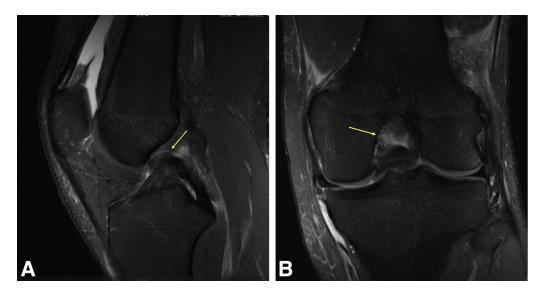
(A) Sagittal T2weighted magnetic resonance imaging (MRI) of the left knee. The MRI demonstrates proximal avulsion of the anterolateral bundle of the posterior cruciate ligament (PCL). The yellow arrow indicates the avulsed PCL fibers. (B) Coronal T2weighted MRI of the left knee. There is proximal avulsion of the anterolateral bundle of the PCL with edema at the medial intercondylar notch, indicated by the yellow arrow.
